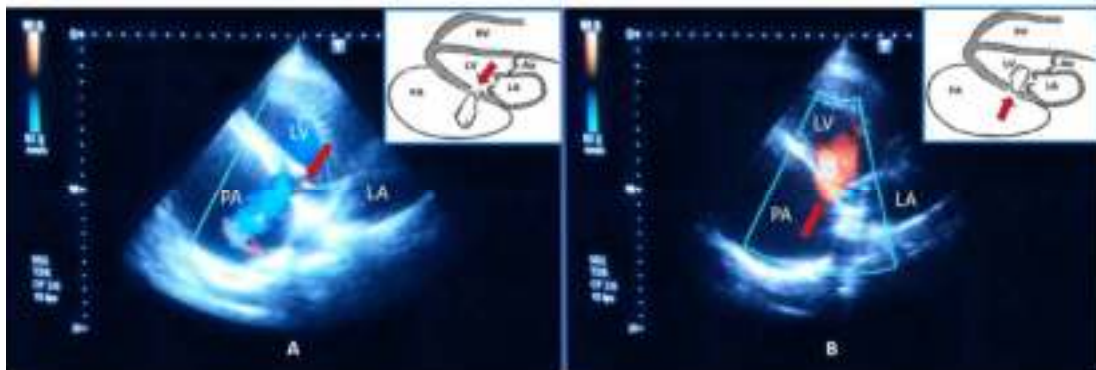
A. Color Doppler echocardiography and scheme. In the projection of the defect, the blue flow indicates cardiac shunt from the left ventricular through the isthmus into the pseudoaneurysm cavity (arrow). B. Color Doppler mapping and scheme. In the projection of the defect, the red flow indicates blood return from the pseudoaneurysm cavity through the isthmus into the left ventricular cavity (arrow).
